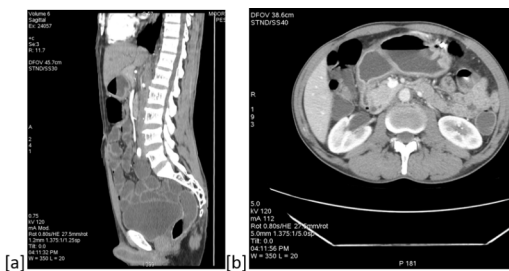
[a]Sagittal and [b] axial contrast CT images showing acute angle of superior mesenteric vein causing compression over the third part of duodenum.
